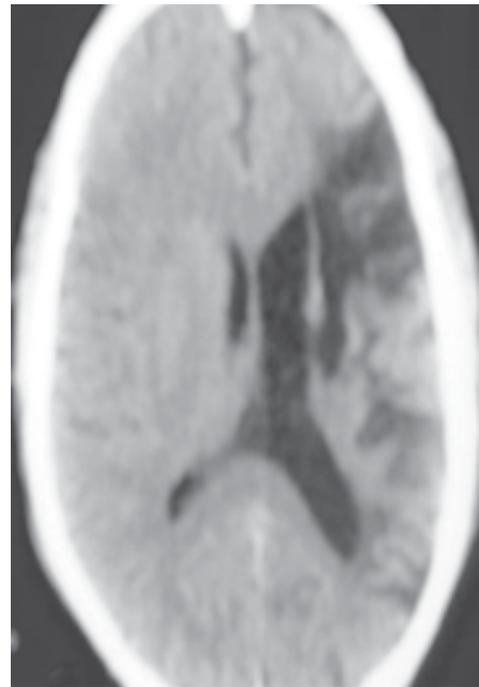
CT scan of brain revealed infarct of left fronto-parietal lobe.
